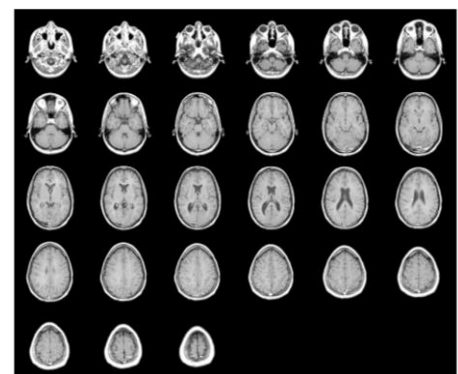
Exploring Slices from an MRI Data Set.
